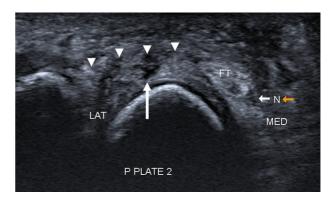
Short-axis ultrasound image of the plantar plate demonstrating heterogeneity in echotexture of the lateral plantar plate and a discrete anechoic cleft (long arrow) indicating a tear (arrowheads). Note the medial migration of the flexor tendon (FT) and abutment with the lateral plantar hallucal nerve (small arrow).
